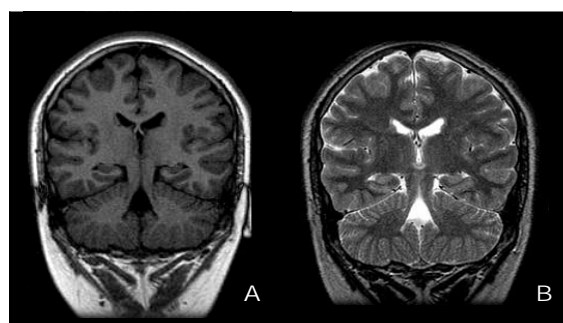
MRI Coronal IR (A) and T2 (B) of a 13- year-old boy who presented with atonic epilepsy, EEG showed epileptiform discharge. Cortical dysplasia at bilateral temporal and right parietal lobes
